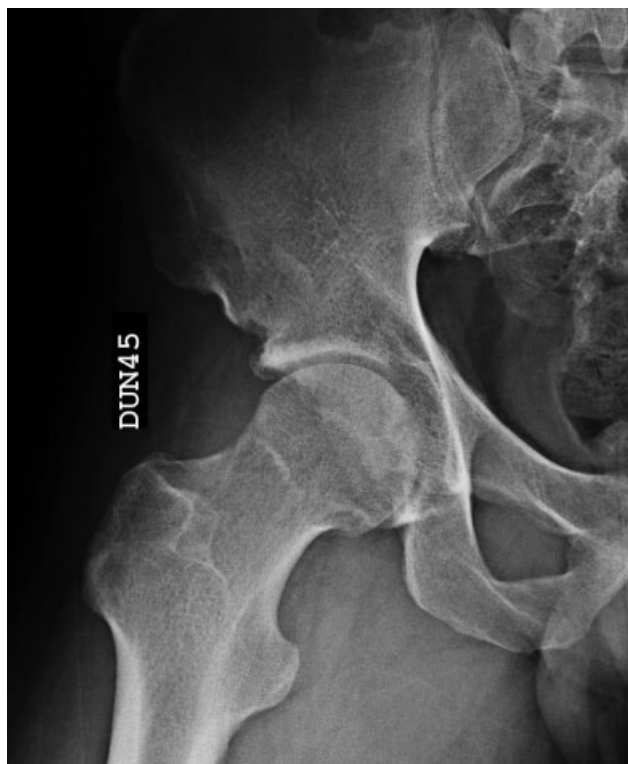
Two-year postoperative radiograph in DUNN 45° view showing the correction of the cam-type deformity. Alpha angle: 38°.
